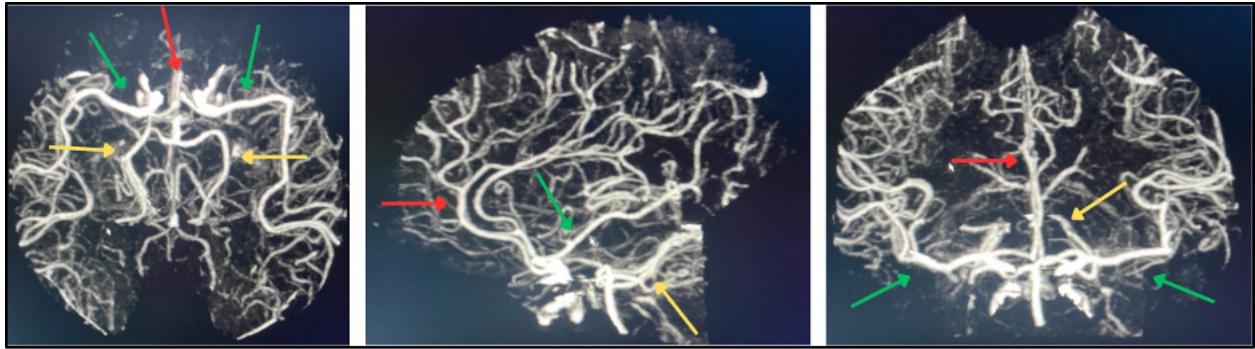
Reconstructed CT angiographic images of the intracranial circulation in (A) axial, (B) sagittal, and (C) coronal projections showing anterior cerebral (red arrow), middle cerebral (green arrow), and posterior cerebral (yellow arrow) arterial territories.
